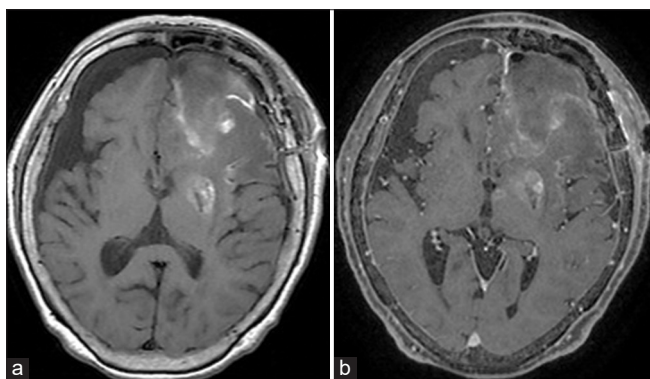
Post tumor resection T1-weighted (a) and Gadolinium-enhanced T1-weighted magnetic resonance imaging (b) showing gross total resection of the tumor.
